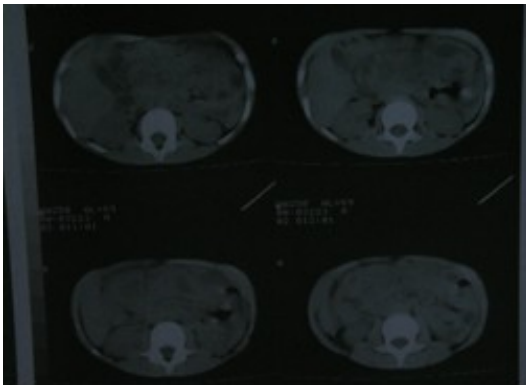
CT view of intra-abdominal fluid collection.
